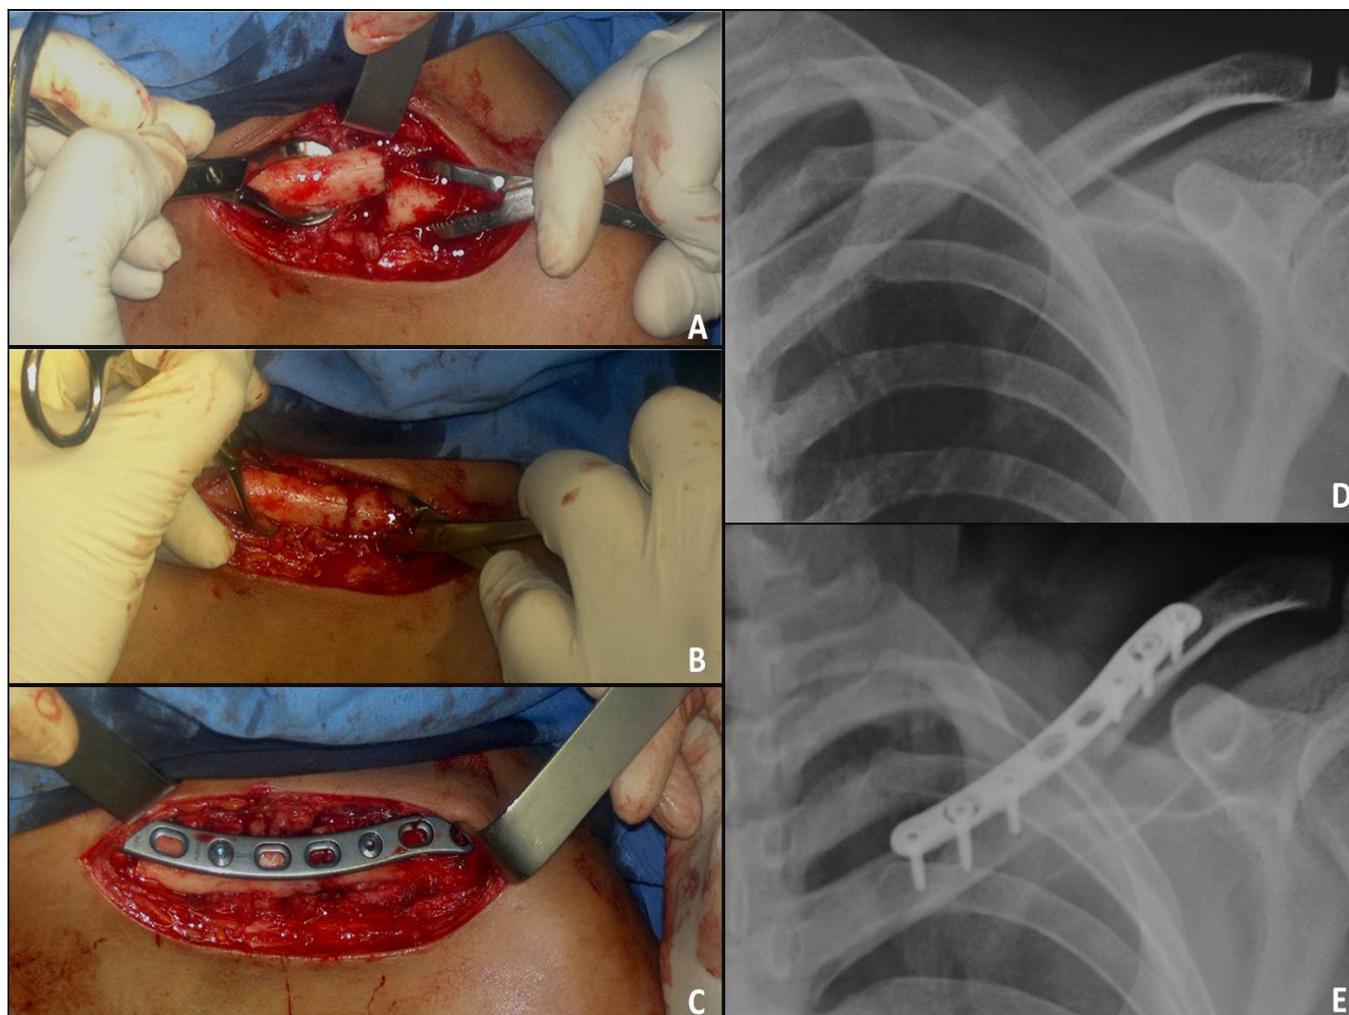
Fracture is exposed through a skin incision following the upper edge of the clavicle (A). Open reduction is performed (B), and the precontoured locking plate is placed on the upper face of the clavicle (C). D and E belong to the pre and postoperative x-rays, respectively.
